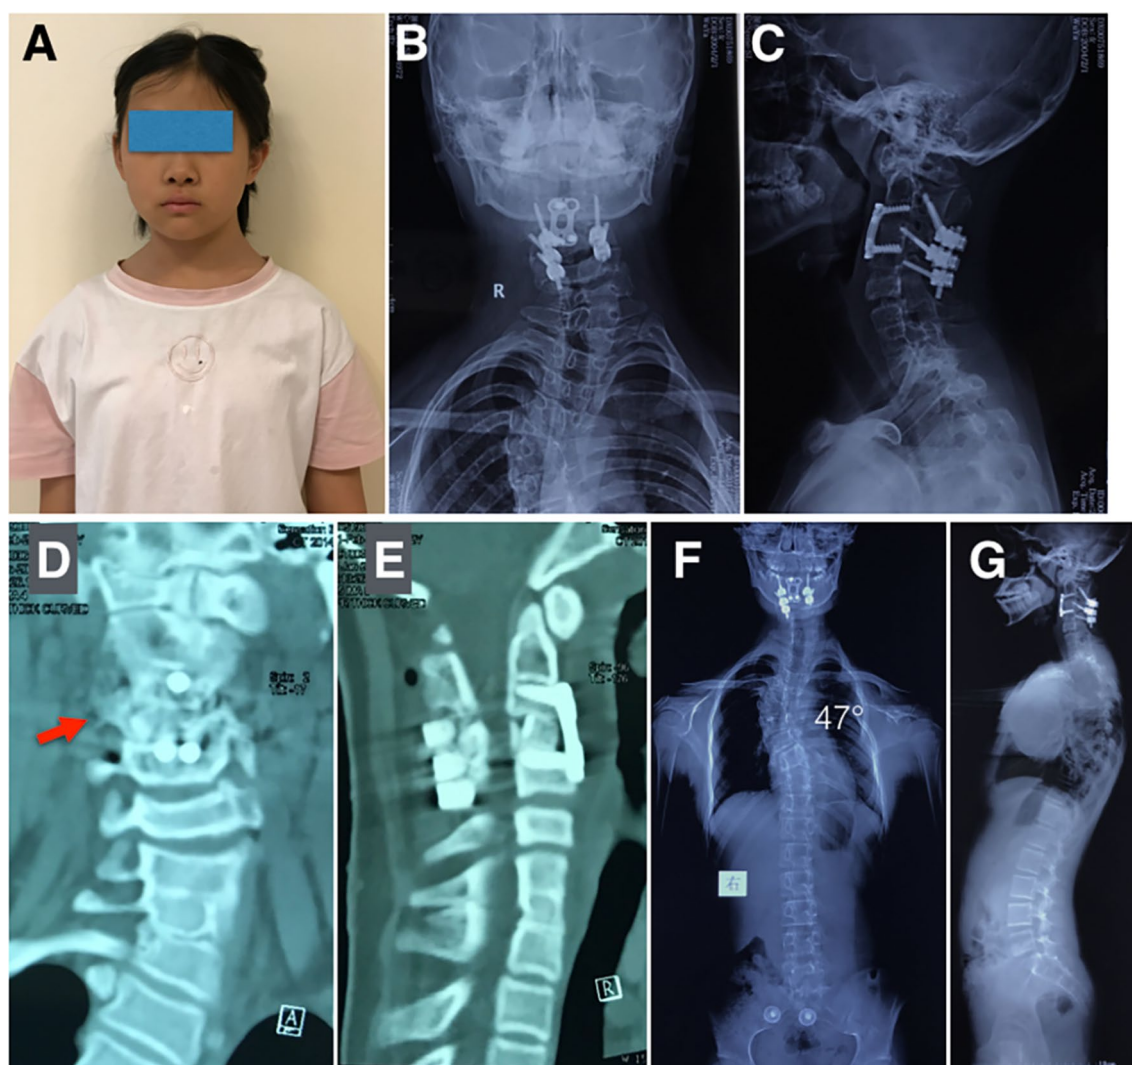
Postoperative images from case 2. a Postoperative clinical photograph showing a neutral head posture. b, c, X-rays showing 0° head tilt. d, e Computed tomographic images obtained at the 1-year follow-up showed the remnant of transverse process and foramen (red
